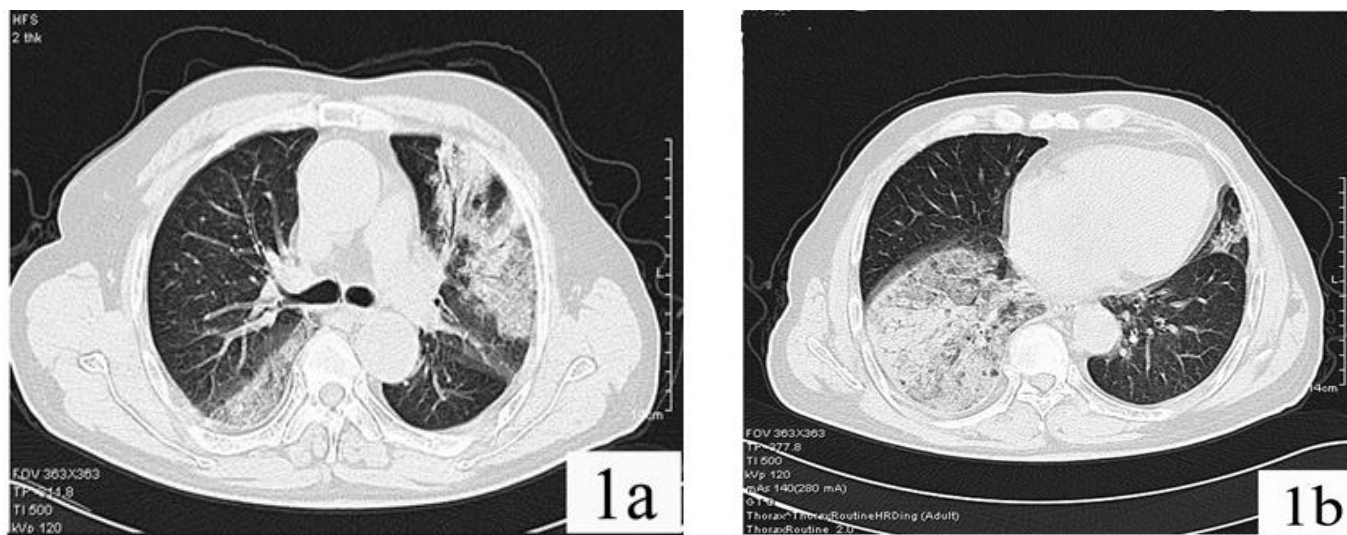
Images of the 1st case: HRCT showed ground-glass attenuation in (a) the left upper lobe and (b) the right lower lobe
